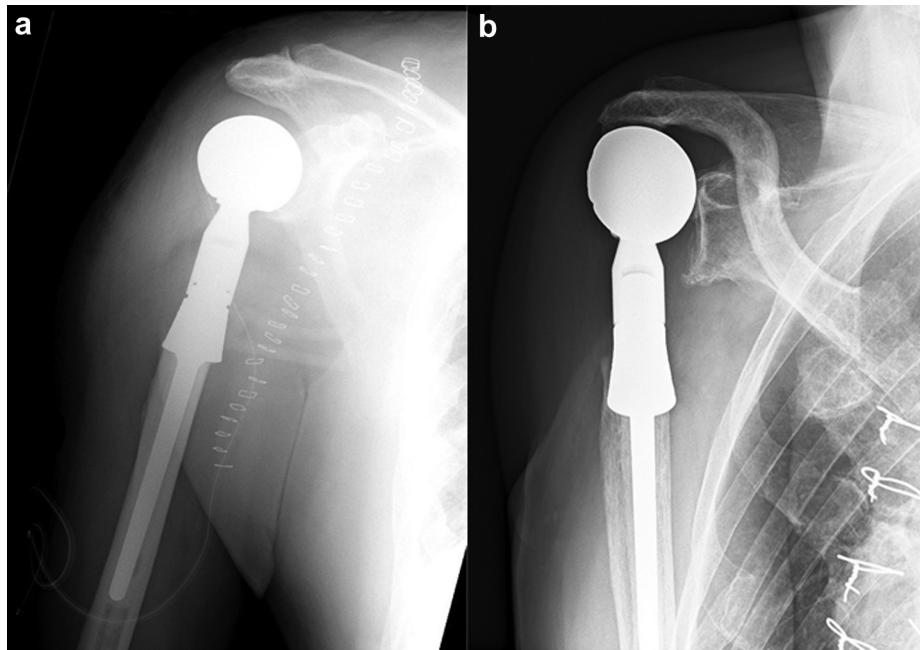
(a) Radiograph in a 65-year-old male patient who underwent placement of an unconstrained hemiarthroplasty (MRS [Stryker, Kalamazoo, MI, USA] modular hemiarthroplasty) for chondrosarcoma in 2009. (b) Radiograph showing proximal migration of the unconstrained hemiarthroplasty in the same patient at 9 years postoperatively.
